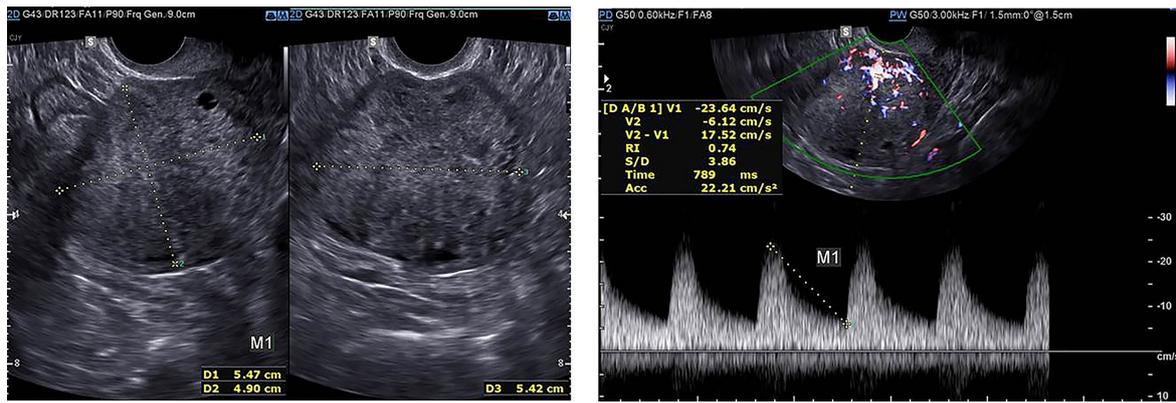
Transvaginal ultrasound findings. Transvaginal ultrasound shows a uterine mass of size $55 \times 54 \times 49$ mm on the fundus with blood supply (RI 0.74).
